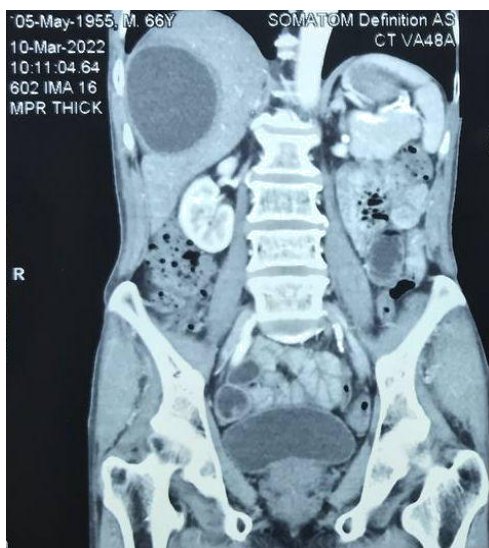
Coronal View of Abdominal CT scan
